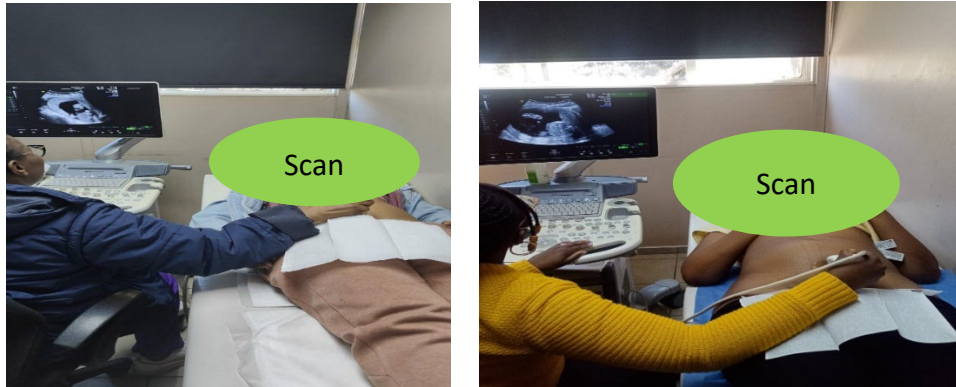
Provision of ultrasound scan services on weekdays and Saturdays
